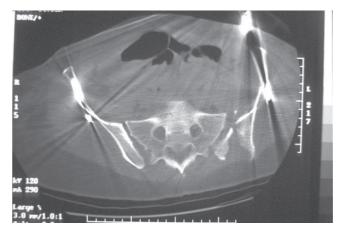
This is an axial CT scan cut through the posterior pelvic ring. It was taken after placement of an external fixator and shows the widely displaced posterior crescent fracture on the left side of the patient. This phenomenon occurred because the surgeon who applied the fixator placed an internal rotation force through the Schanz pins that were placed in the ilium.
